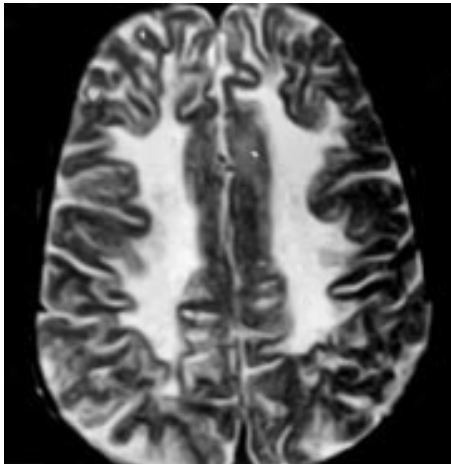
T2-weighted MRI scan showing diffuse white matter demyelination in an 8-year-old boy with SSPE.
